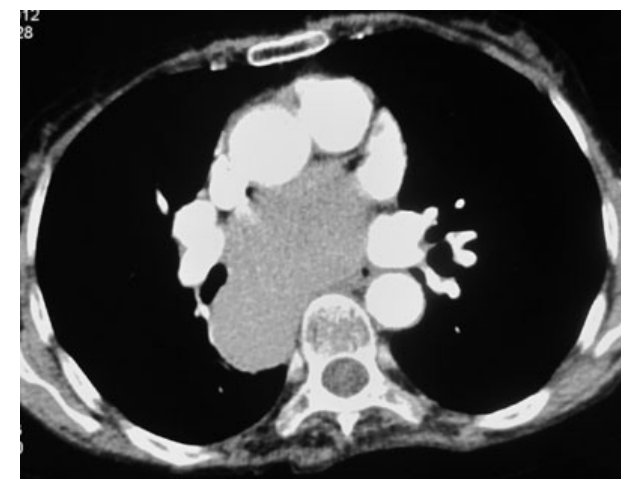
Thorax CT in mediastinal window showing cystic lesion at subcarinal paraesophageal location.
